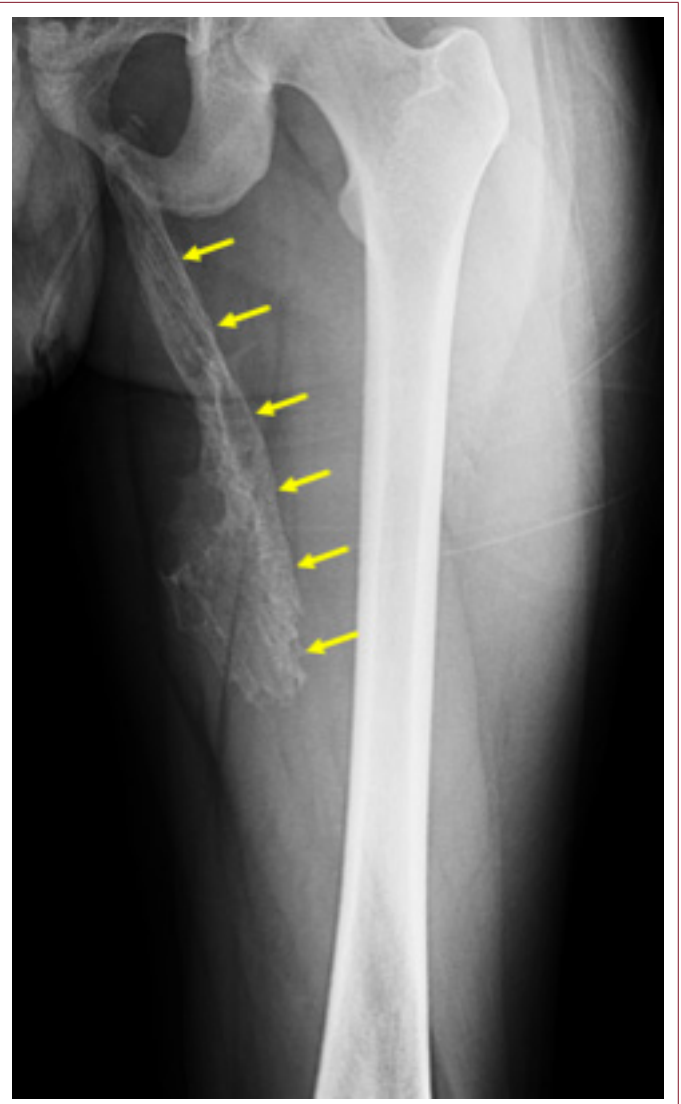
The follow-up anteroposterior radiograph of the left hip and proximal femur was obtained eight months after the initial injury. Mature, linear, and trabeculated ossification is visible along the course of the adductor longus muscle (yellow arrows), consistent with myositis ossificans.
